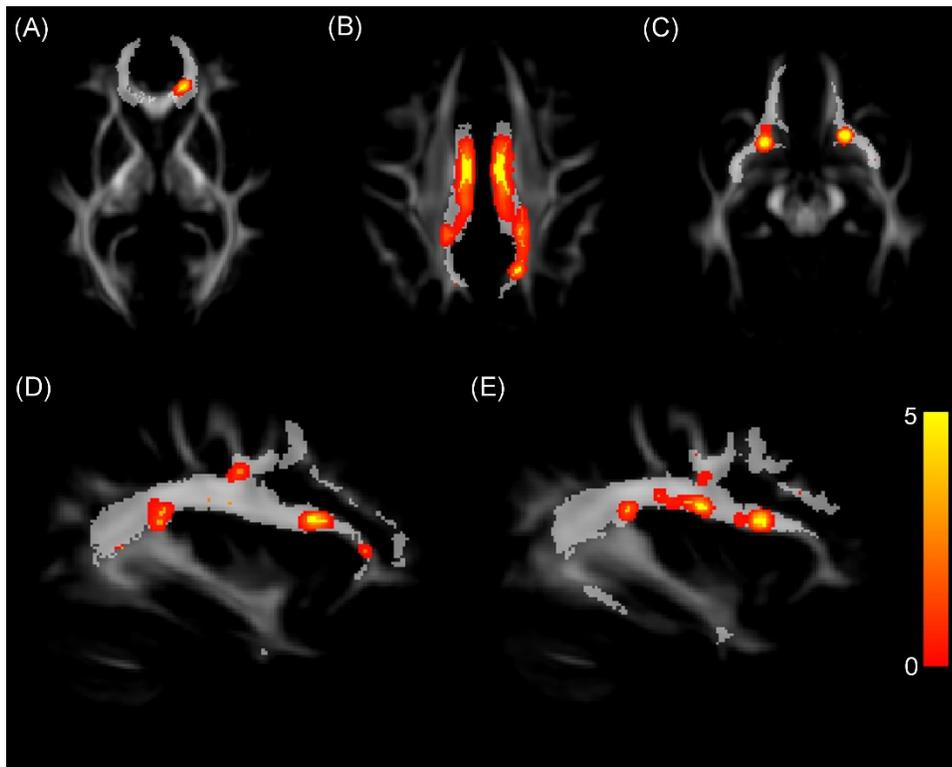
Regions of Interest (ROIs) for MRI analysis.
